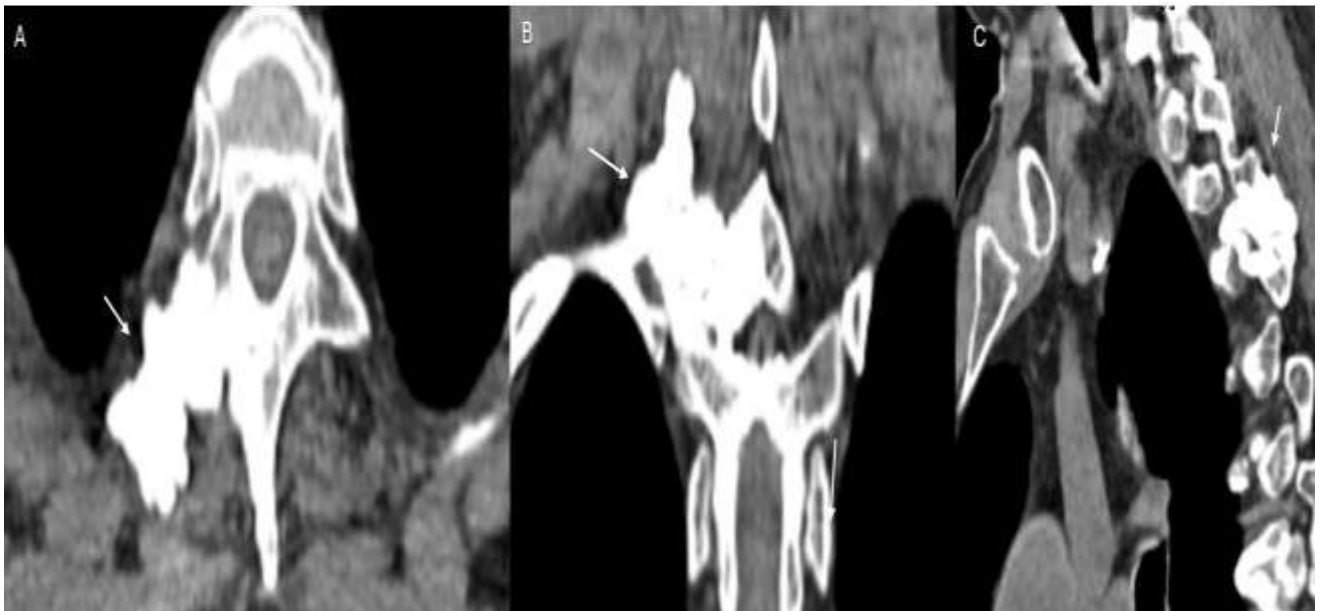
Computed tomography (bone window) images of the thoracic spine and adjacent rib demonstrating eccentric unilateral cortical hyperostosis. (A) Axial image shows dense flowing cortical thickening along the posterolateral aspect of the D3 vertebral body extending into the posterior elements (arrow). (B) Coronal reconstruction demonstrates linear undulating cortical hyperostosis along the vertebral body and adjacent rib (arrow). (C) Sagittal reconstruction confirms flowing cortical thickening without cortical breach, medullary destruction, or associated soft tissue mass (arrow).
